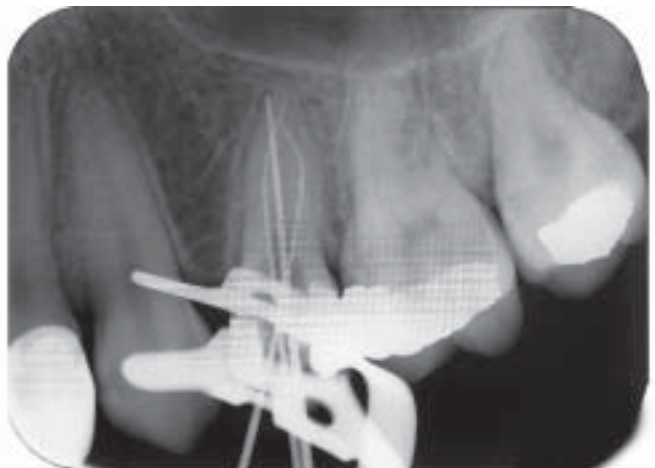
Working-length determination radiograph with three endodontic instruments.
